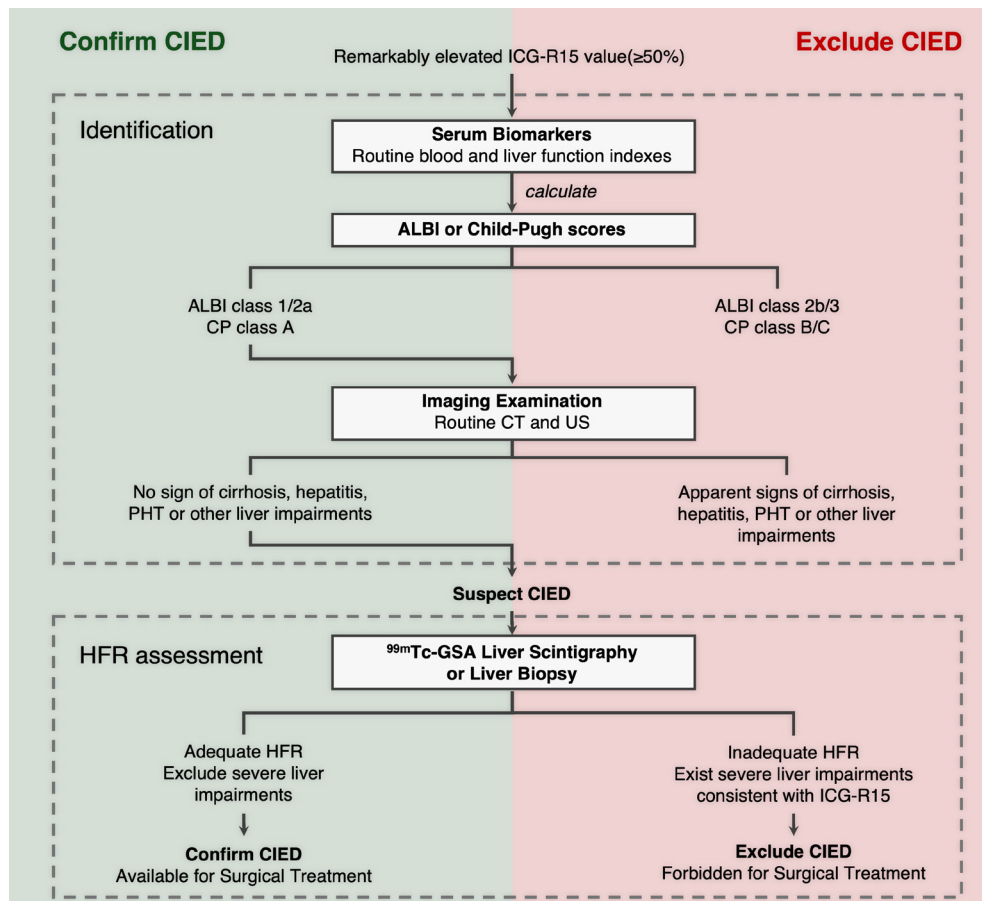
A strategy to cope with unexplained high ICG retention patients. CIED: constitutional indocyanine green excretory defect, ICG-R15: plasma indocyanine green retention rate at 15 minutes, ALBI: albumin-bilirubin scores, CT: computer tomography, US: ultrasonography, PHT: portal hypertension, HFR: hepatic functional reserve, ^{99m}Tc-GSA liver scintigraphy: ^{99m}Tc-Galactosyl human Serum Albumin liver scintigraphy.
